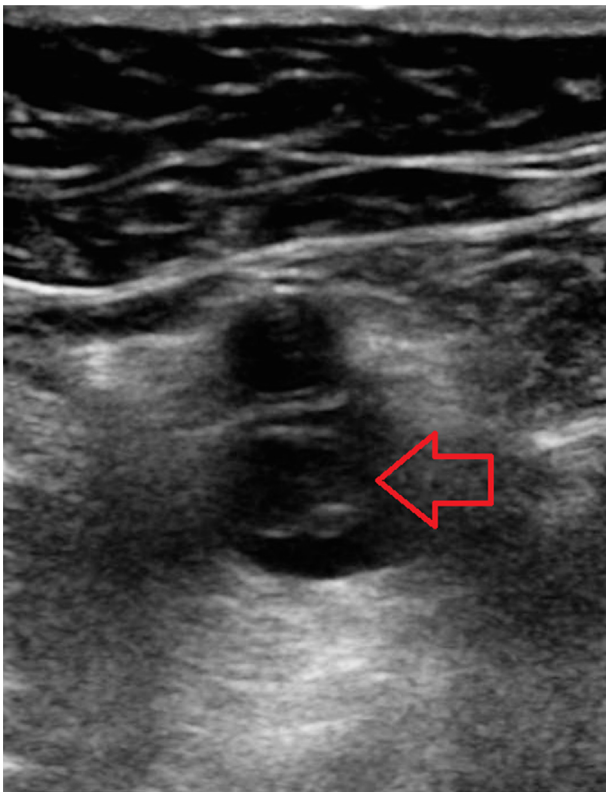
Sonogram of the left femoral vein in a 61-year-old man shows a large occlusive thrombus observed in the noncompressible left femoral vein (arrow).
